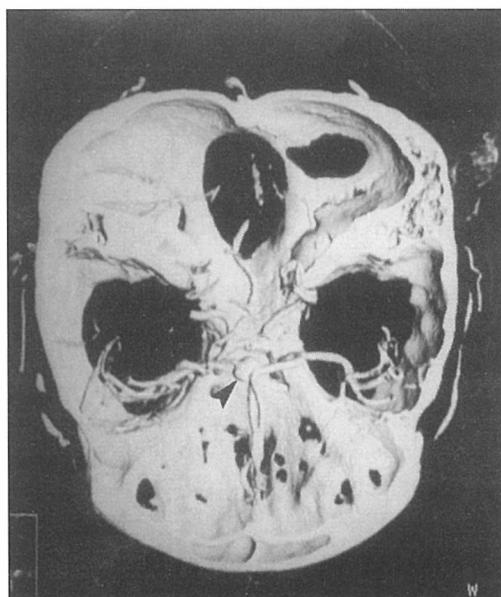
Three-dimensional computed tomographic angiographic image, superior view, demonstrates a 9-mm-diameter anterior communicating artery aneurysm (arrow).
